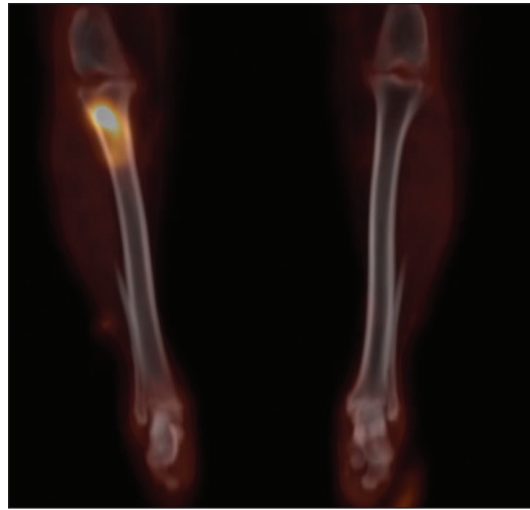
PET/CT reconstruction image showing an intensely hypermetabolic lesion (34 mm, SUV_{max} 9.14) in the right proximal tibial metaphysis.
